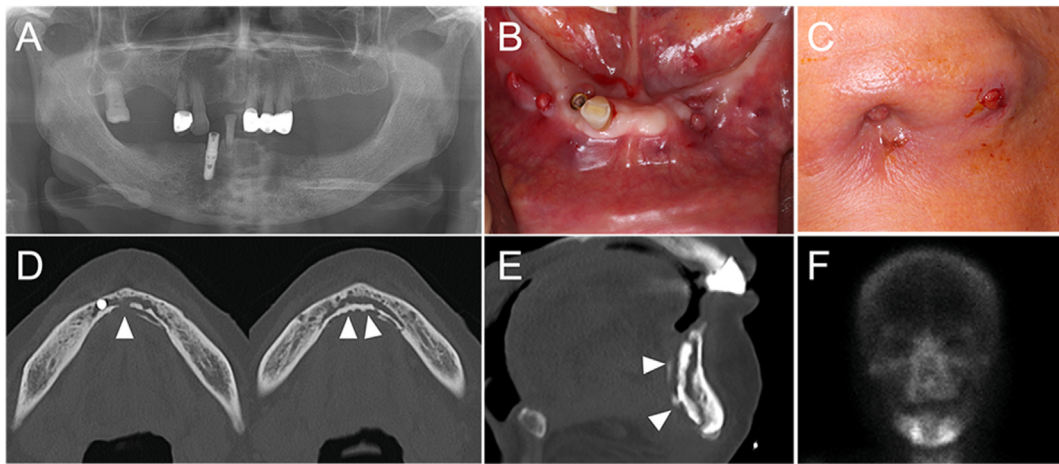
Preoperative radiographs and clinical photographs of Case 2. (A) Panoramic view. (B) Intraoral clinical photograph. (C) Extraoral clinical photograph. (D, E) Computed tomography images showing sequestrum formation (arrowhead) along the lingual aspect of the anterior mandible, extending to the inferior border. (F) Bone scan.
